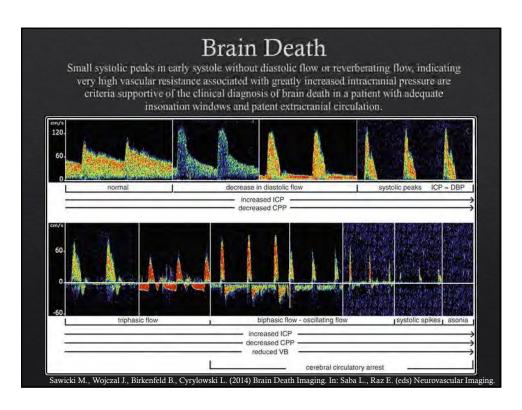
Image from https://slideplayer.com/slide/4898934/ University of Oklahoma Ryan Hakimi 2015 Introduction to Carotid and Transcranial Doppler Ultrasound
